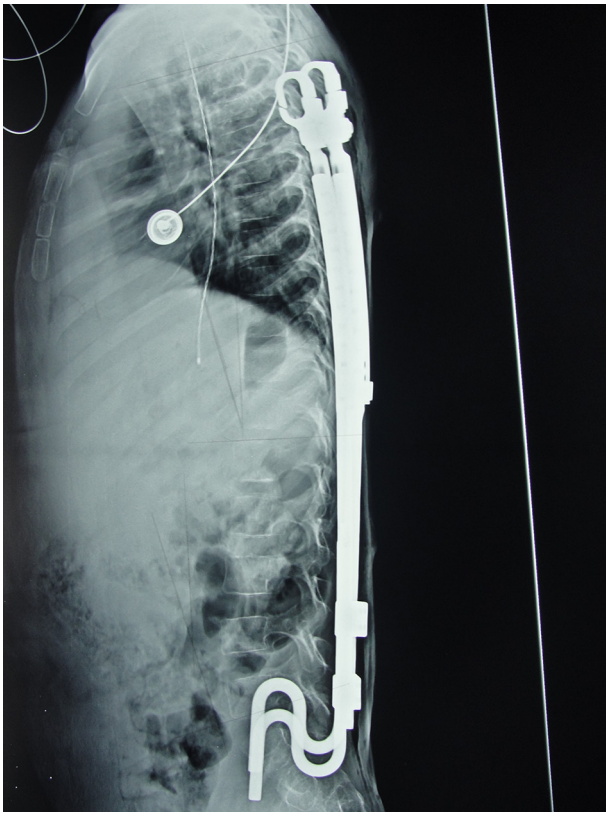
Lateral Radiograph 8-Year-Old Boy Patient With None Ambulatory Myelomeningocele Status Post Bilateral Rib to Pelvis VEPTR
